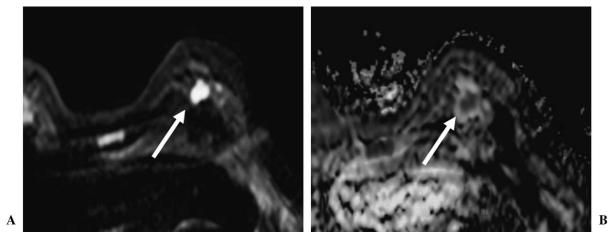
A 46-year-old woman with left breast cancer diagnosed as axillary lymph node (N)-negative, nuclear grade (NG) 2, estrogen receptor (ER)-positive, progesterone receptor (PgR)-positive, and human epidermal growth factor receptor 2 (HER2) score 0. (A) A nodule with high signal intensity was detected in the left breast on diffusion-weighted imaging (DWI) (arrow). (B) The apparent diffusion coefficient (ADC) value was found to be 0.73×10^{-3} mm²/s on the ADC map.
